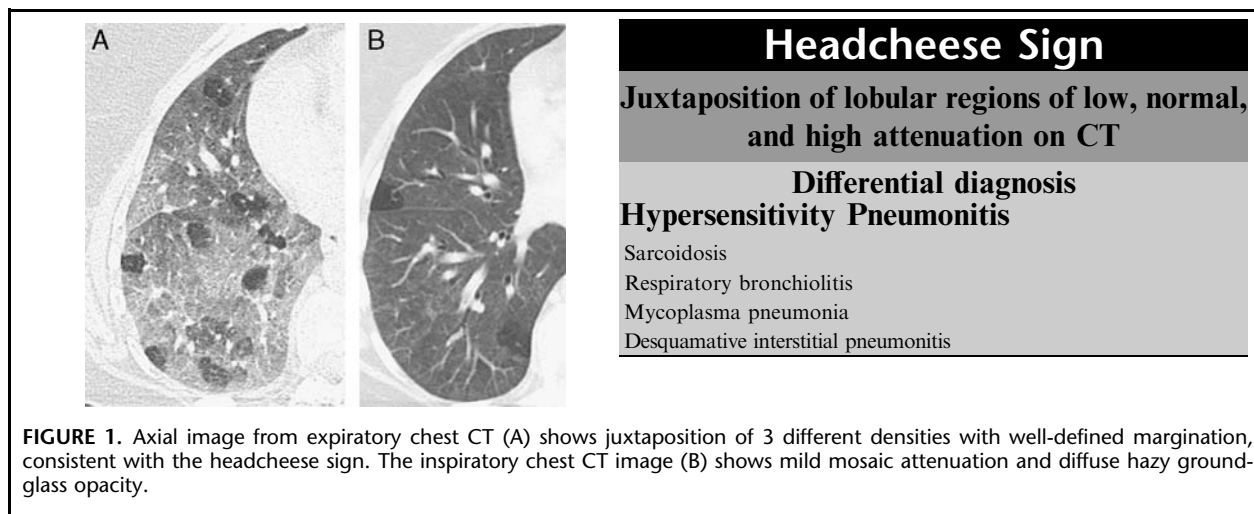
Axial image from expiratory chest CT (A) shows juxtaposition of 3 different densities with well-defined margination, consistent with the headcheese sign. The inspiratory chest CT image (B) shows mild mosaic attenuation and diffuse hazy ground-glass opacity.
